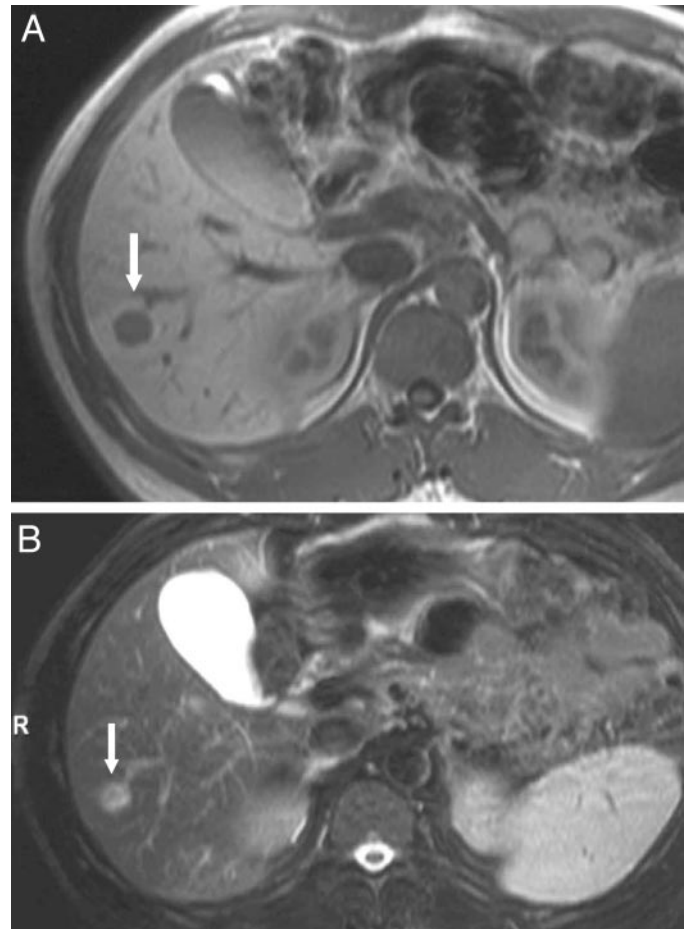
A, T₁-weighted MRI of a hepatic metastasis (*white arrow*) in a patient with a metastatic NET. The lesion is hypodense compared to the surrounding liver parenchyma. B, T₂-weighted MRI in the same patient. Note that the lesion (*white arrow*) is now hyperintense (courtesy of Dr. A. G. Rockall and Dr. R. Reznick, Department of Radiology, St. Bartholomew's Hospital, London, UK).
